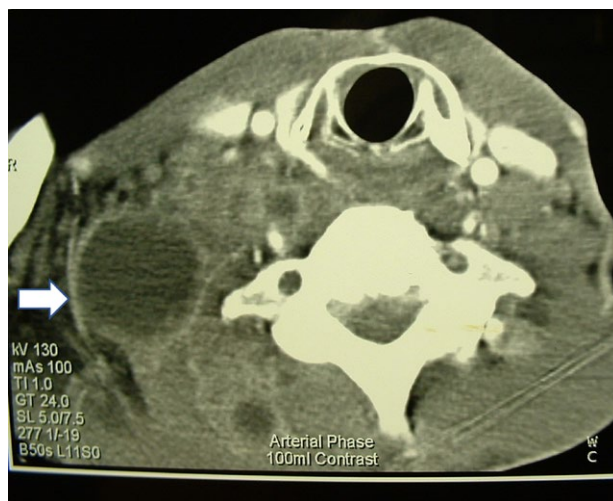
Large right supraclavicular node (arrowed) with rim enhancement and central hypodensity representing caseous necrosis on CT – typical appearance of a TB node.
